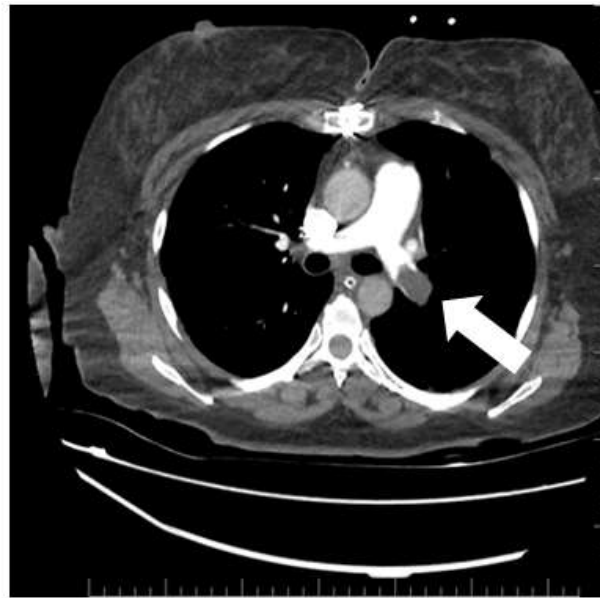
The CT thoracic angiography shows embolism in the left main pulmonary artery (white arrow).
